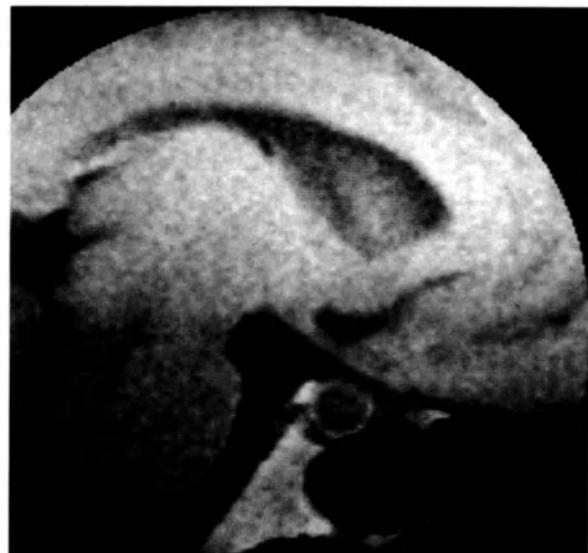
Pituitary microadenoma shown by MRI (proton density).
